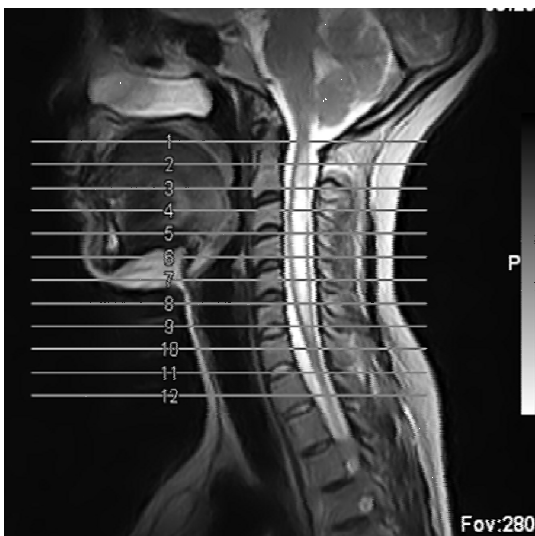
T2W1 MRI of cervical spine of the patient -hyper intense signal intensity (arrow) intramedullary lesion extending from C1-C7 vertebra
